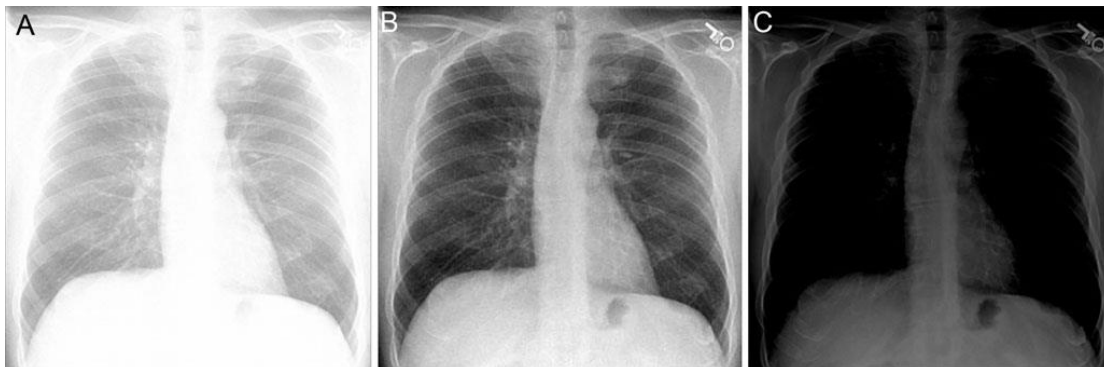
Responses of a screen-film detector with a fixed radiographic speed.
